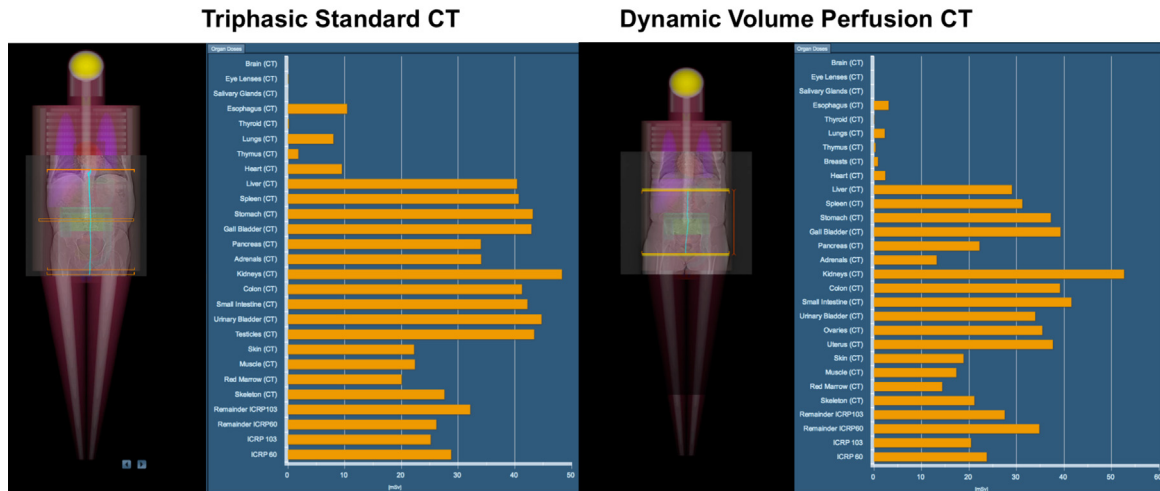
Two exemplary, water-equivalent-diameter-matched exams of two males patients with suspected hepatocellular carcinoma. On the left side, the dynamic volume perfusion exam is shown, on the right side the triphasic standard CT.
